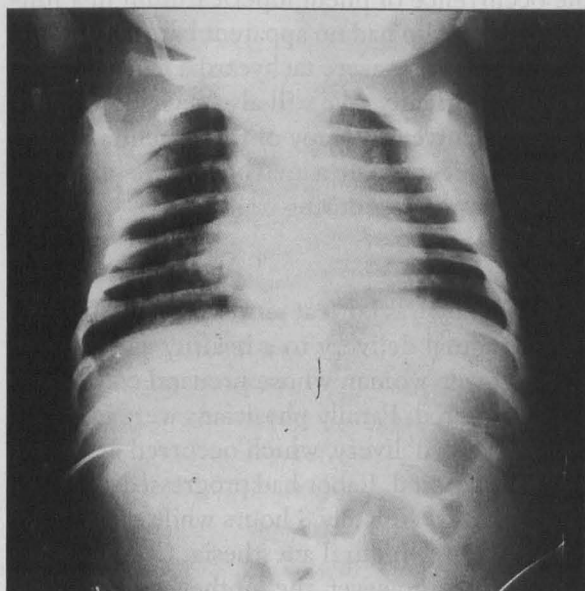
Chest radiograph, day 2, showing resolution of the pericardial air.
